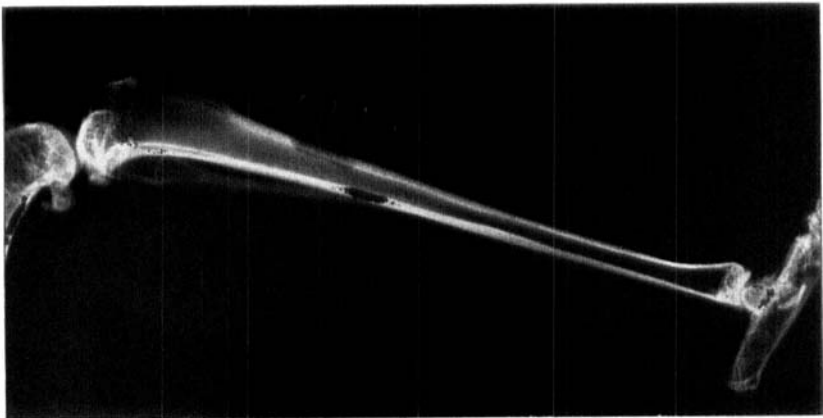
b. X-ray photograph of the bone cavity.
